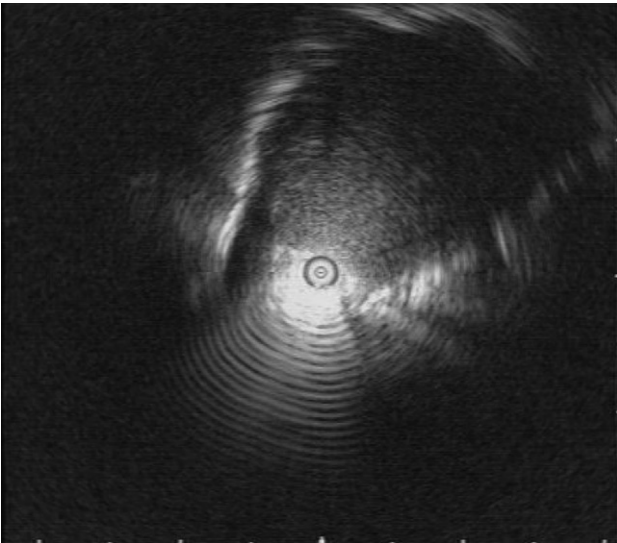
EBUS image of parabranchial pulmonary nodule. EBUS = endobronchial ultrasound.
